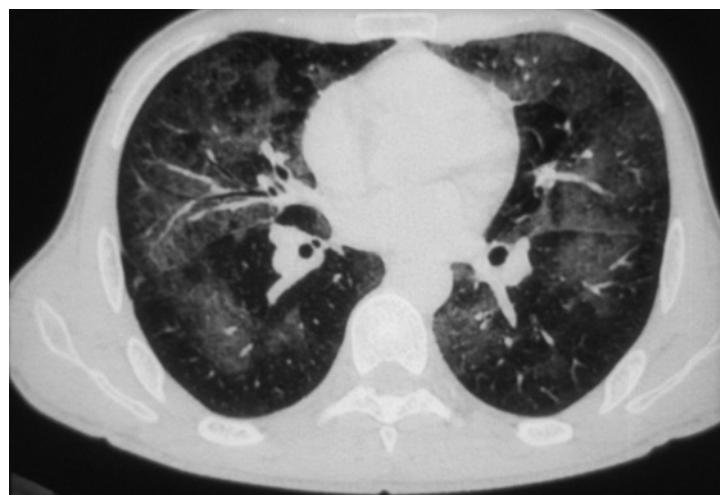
Classic picture of *Pneumocystis carinii* pneumonia. CT clearly demonstrates the position of the ground-glass opacities in the central lung, sparing the periphery. There is also some sparing of the peribronchovascular region.
